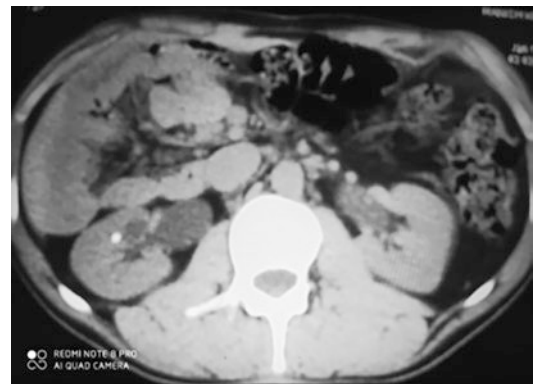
Only transverse sections of CT images could conclusively demonstrate that this stone is lying in anterior calyx
